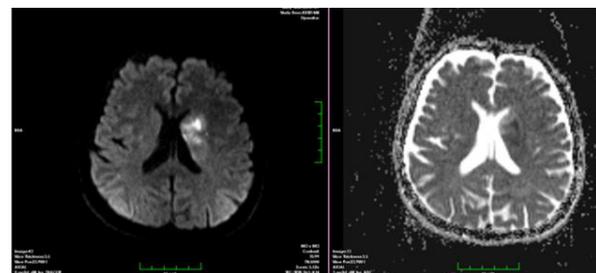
In the diffusion MRI examination, acute diffusion restriction in the left caudate nucleus and the anterior of the lentiform nucleus.
